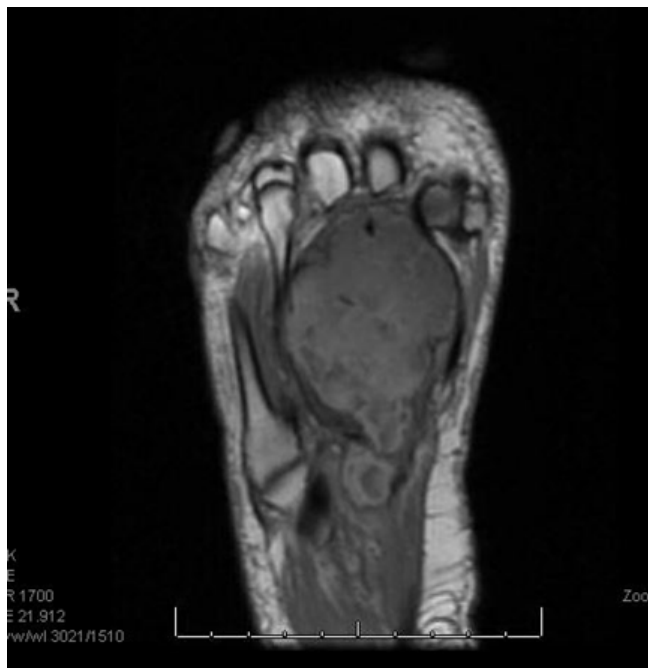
MRI axial view right foot.
